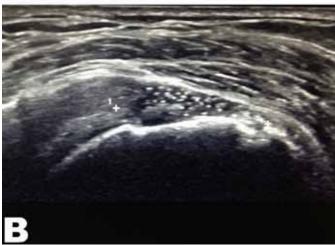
(A) Ultrasound examination prior to PRP therapy showing the insertional supraspinatus partial tear (B) Ultrasound examination at 52nd week post-commencement of PRP therapy showing ingrowth of hyper-echoic fibrous tissue which does not exhibit tendon 'like' structure.
